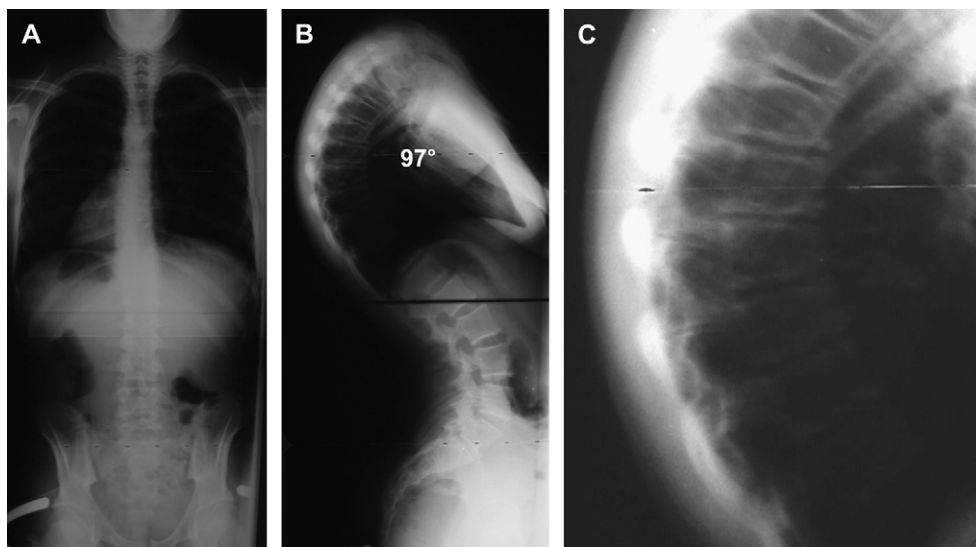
(A) Anteroposterior, (B) lateral, and (C) focused radiographs of a patient with Scheuermann's disease. (C) Note the sharp angular kyphosis and wedging of the apical vertebrae and narrowing of intervertebral discs.
